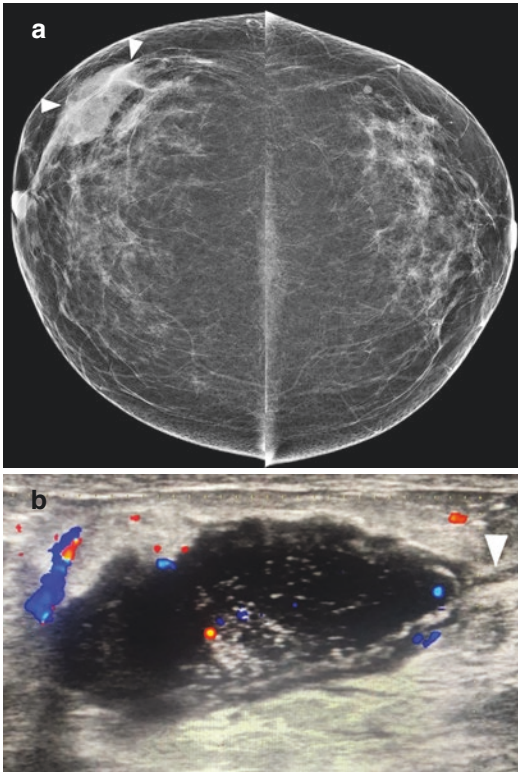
Right tuberculous mastitis in a 36-year-old woman who presented with a recent palpable lesion. (a) Bilateral craniocaudal (CC) mammograms show an ill-defined mass (arrowheads) and trabecular thickening in right breast. (b) Corresponding color Doppler US image shows parenchymal edema in the right breast with an abscess and fistula tract (arrowhead). (Courtesy of Dr. Tanvi Jakhi, Mammocare, Mumbai, India)
